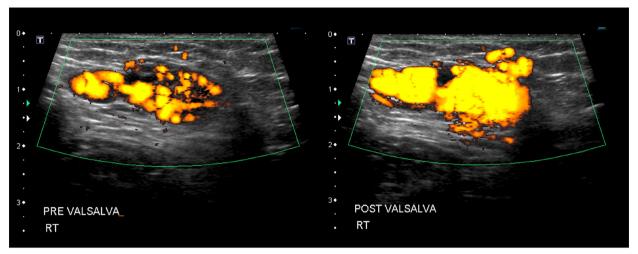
Ultrasound imaging of the right inguinal region. Venous structures show engorgement with Valsalva maneuver, reaching anteroposterior (AP) diameters of at least 7 mm. There is no evidence of thrombus formation.
